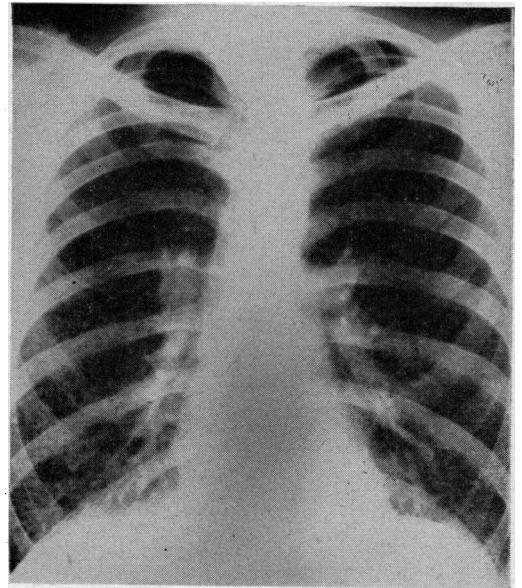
Chest radiograph showing fine granular mottling in mid and lower zones of both lung fields
